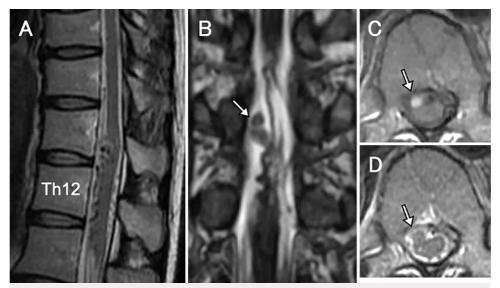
Follow-up MRI 4 months after embolization. A: Sagittal T2-weighted image. B: Coronal 3D FIESTA image. C: Axial T1-weighted image. D: Axial T2-weighted image. The images show thrombosed aneurysm (*arrows*) and decreased size of the nidus.
